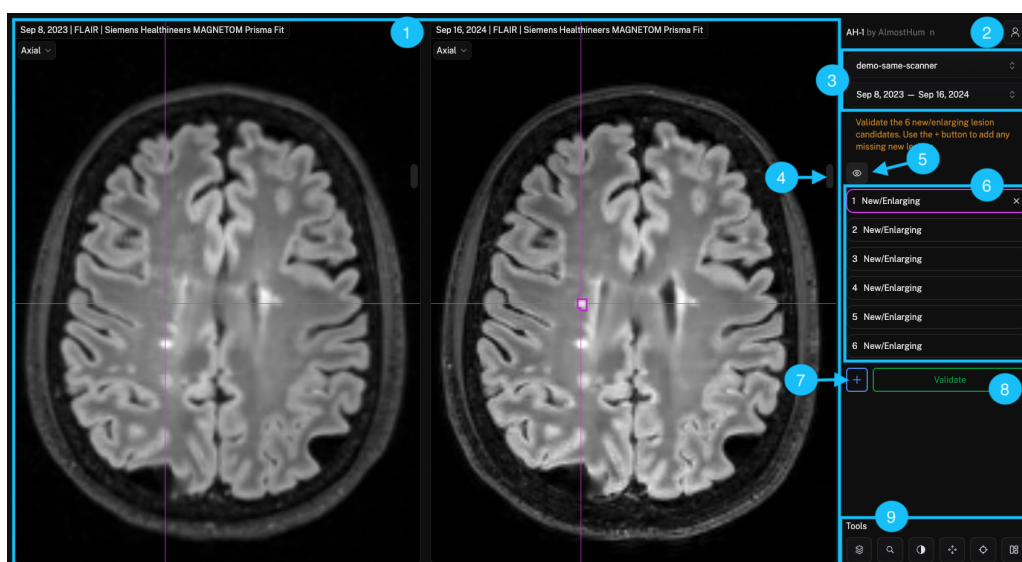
Case screen: 1. MRI images time points visualization. 2. Profile button. 3. Information related to the case. 4. Vertical scrollbar. 5. Eye toggle. 6. New lesion candidates list. 7. Adding missing lesions button. 8. Validation button. 9. Tools.
